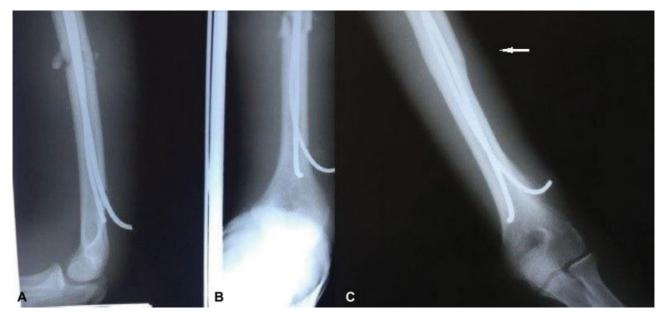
Profile and anteroposterior radiographs showing the adequate fixation with flexible rods (A) and (B); fracture consolidation after 5 months (C).
